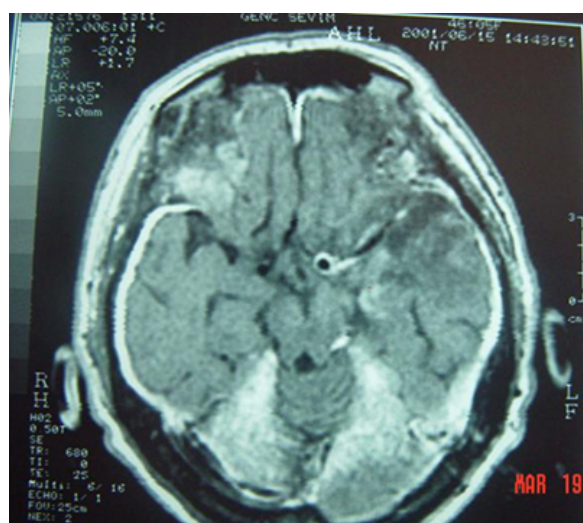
Contrast-enhanced T1-weighted axial MR image reveals diffuse thickening and contrast enhancement of dura mater and tentorium.
